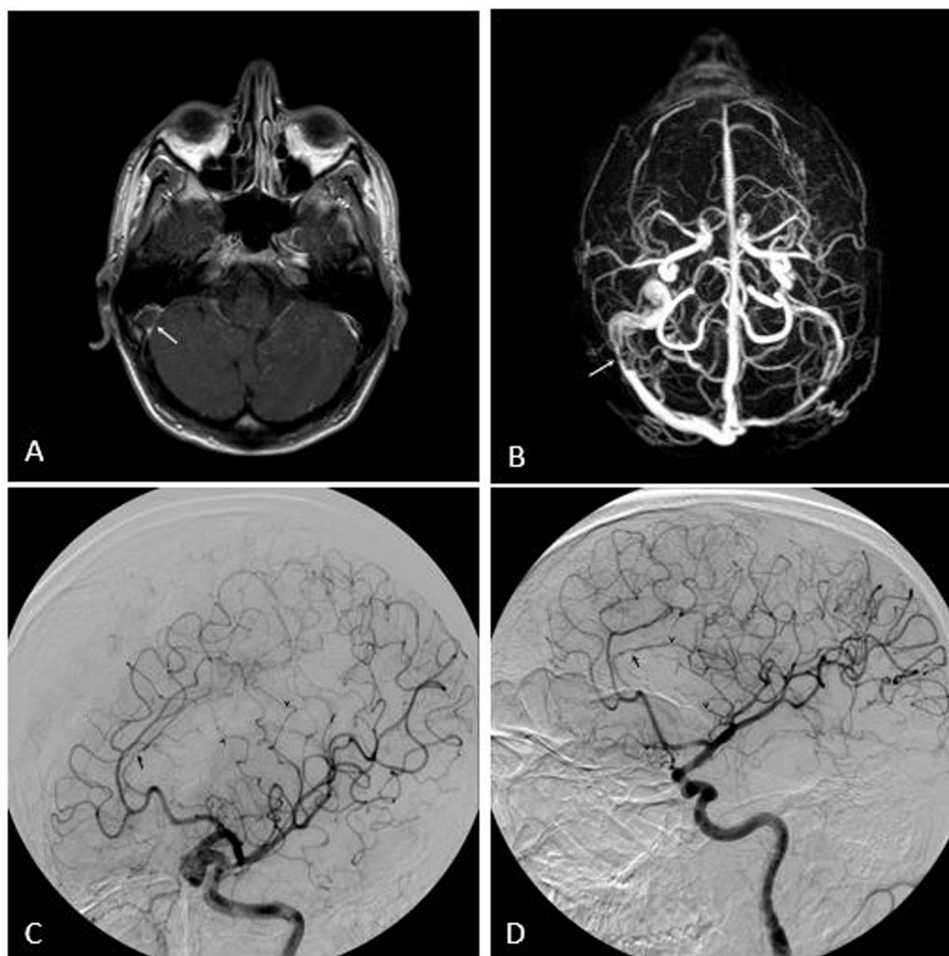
Cerebral vascular alterations. (A) An axial contrast enhanced T1 MRI with gadolinium demonstrating a filling defect at the right sigmoid sinus (with the arrow) and (B) TOF MRI showing CSVT (white arrow); (C-D) DSA showing diffuse arterial stenosis and dilatation (black arrows).
